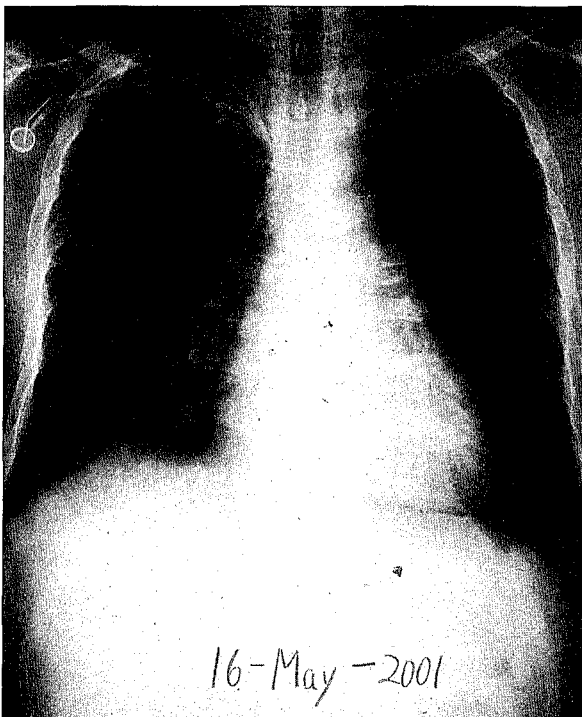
Chest X-ray shows an improvement in the cavitary nodular lesions after amphotericin B therapy.
